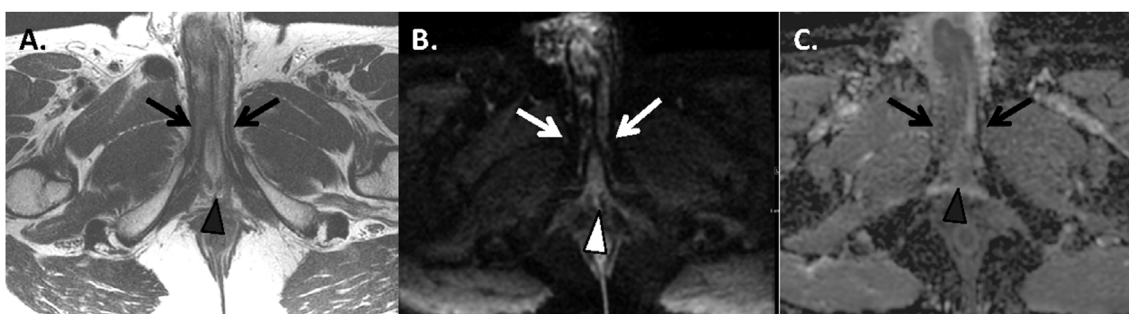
Post treatment MRI following 8 cycles of chemotherapy: (A) axial T2 image without fat saturation, (B) axial diffusion weighted imaging (DWI) and (C) axial apparent diffusion coefficient (ADC). Decreased penile engorgement. Improved T2 signal and less restricted diffusion at the bulb of the penis (arrowhead), and bilateral corpora cavernosa (arrows).
